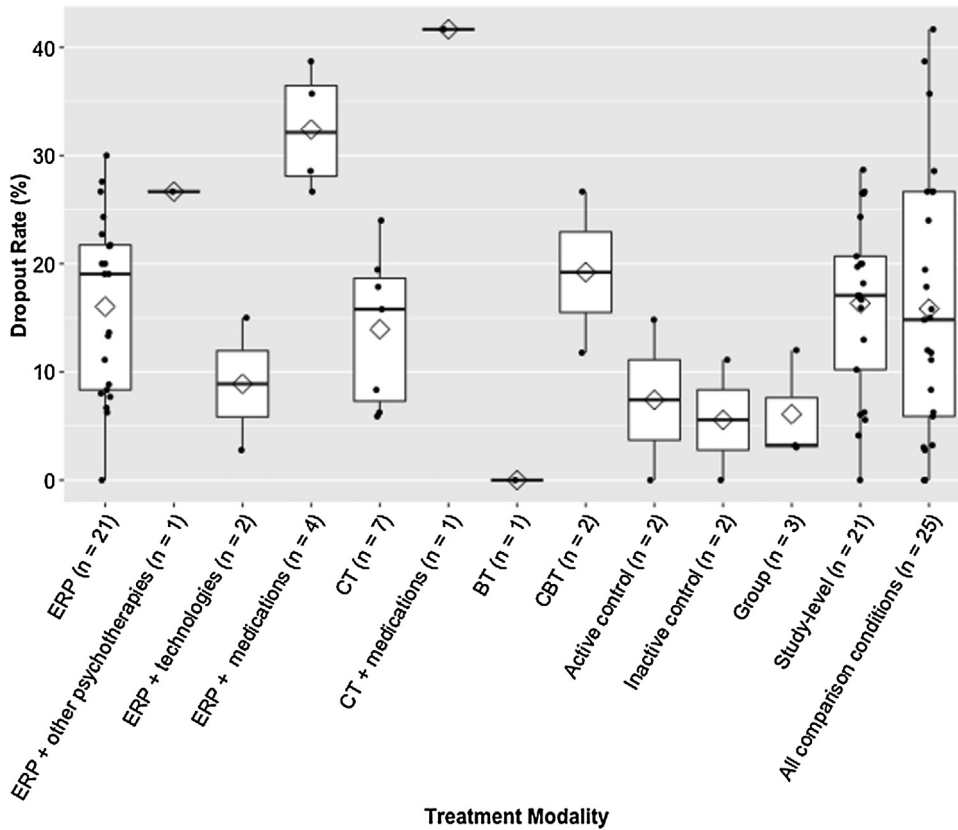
Dropout rates by treatment modality. Note: ERP = exposure with response prevention; CT = cognitive therapy; BT = behavior therapy; CBT = cognitive behavioral therapy.
